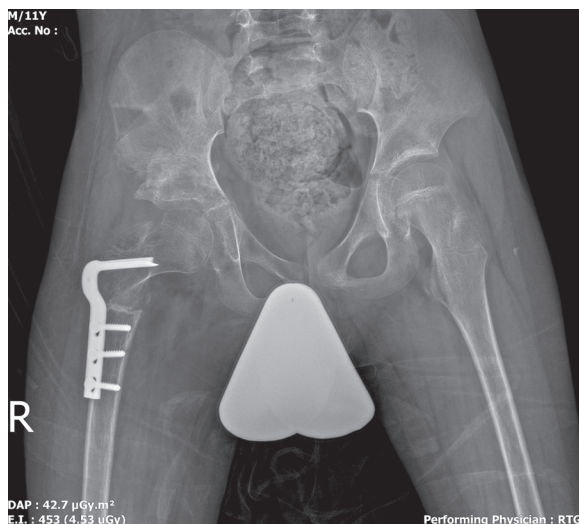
Postoperative right hip radiograph. Note the ring of femoral bone acquired during femoral shortening osteotomy used as bone graft at the site of the pelvic osteotomy.
